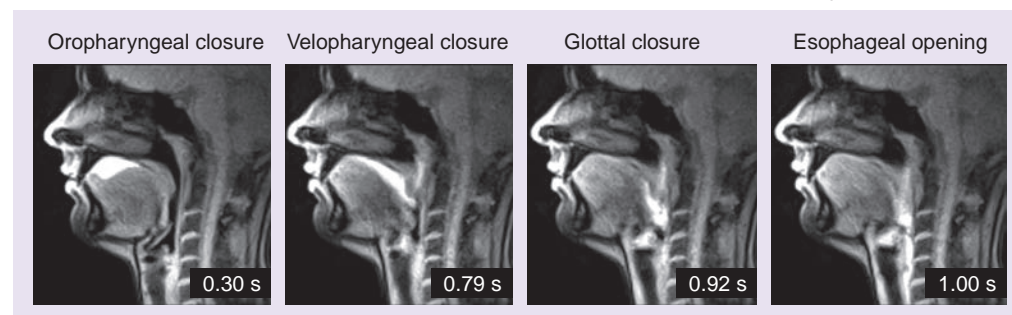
Real-time MRI of natural swallowing using 5 ml pineapple juice as MRI ‘contrast’ agent. Selected frames from a respective movie at 41 ms temporal resolution (24 fps) acquired using radial fast low-angle shot (19 spokes, repetition time/echo time = 2.17/1.44 ms, flip angle 5°, 1.5 × 1.5 × 10.0 mm³). The images represent distinct swallowing events with relative timings to the beginning of the esophageal opening (i.e., 1.00 s). For a corresponding dynamic visualization of movements during speaking see SUPPLEMENTARY MOVIE 2.
